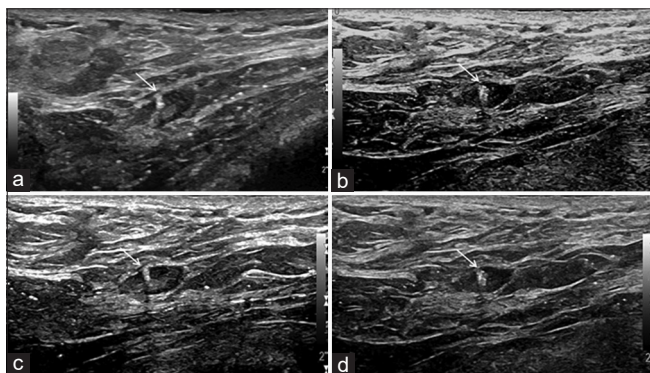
Optimization of frequency in a cadaver model. Ultrasound (US) transducers are specified by their center frequencies but operate within a range of frequencies or bandwidth. Breast US typically uses a few transducers to provide frequencies in the 7 MHz–18 MHz range. Although higher frequencies offer higher resolution, the depth of penetration through soft tissues is lower, making higher frequencies better for superficial imaging and lower frequency better for imaging deeper soft tissues. The biopsy marker is an echogenic focus in each image (arrow). The default biopsy mode uses 11 MHz (a). The adjustments were 9 MHz (b), 13 MHz (c), and 15 MHz (d). The preferred frequencies for this case were 13 MHz and 15 MHz, all higher than the default. This could be related to the depth of the target for this case. As a rough approximation, the depth of penetration can be estimated by  $(60 \text{ cm MHz})/f$ , where  $f$  is in MHz. Using this rough calculation in this particular case, a 60 MHz center frequency transducer might be helpful for this depth of penetration. However, this rough calculation is affected by the attenuation coefficient, an indicator of acoustic loss, which can be quite variable depending on the insonated soft tissues.<sup>[12]</sup> In this case, increasing the frequency narrows the width of the ultrasound beam which makes it more and more difficult to get around the marker and thus makes the shadow prominent.
